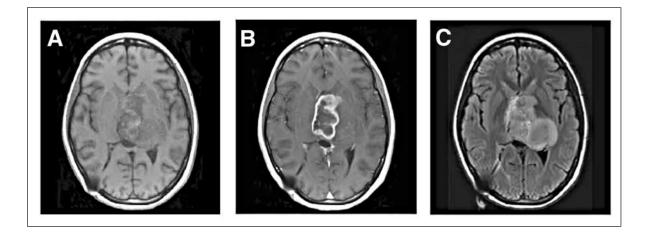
MRI scans of a patient with left thalamic GBM. A and B) T1-weighted axial views without and with contrast. C) Axial fluid-attenuated inversion recovery (FLAIR) image.
